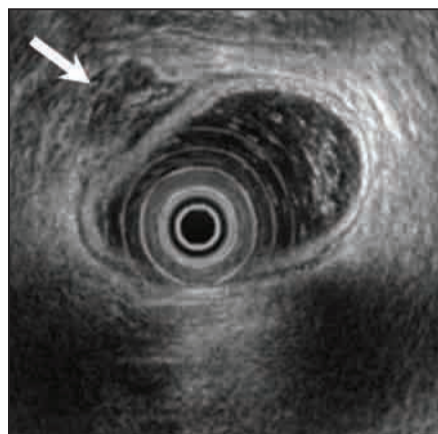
The rectal endoscopic ultrasound in a case of rectal endometriosis is on top, with the surgical finding on the bottom.
